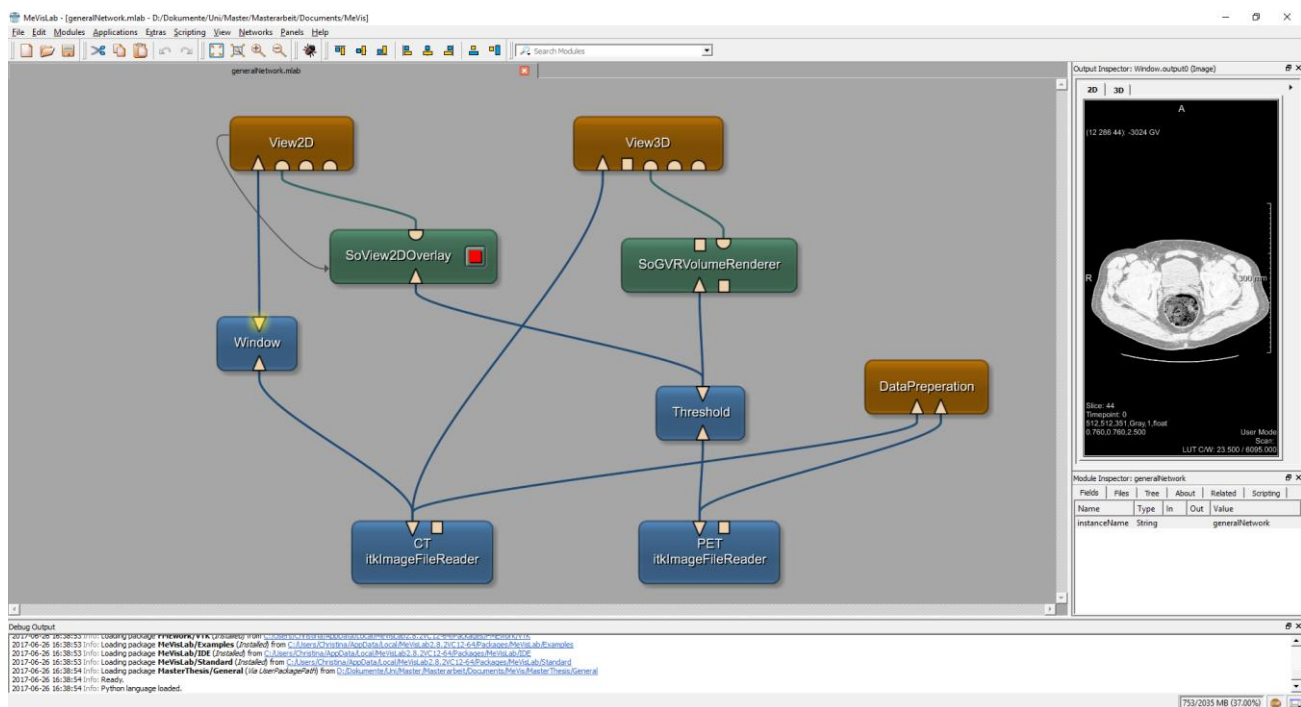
General Network for loading, processing and visualizing PET and CT data, implemented in MeVisLab.
